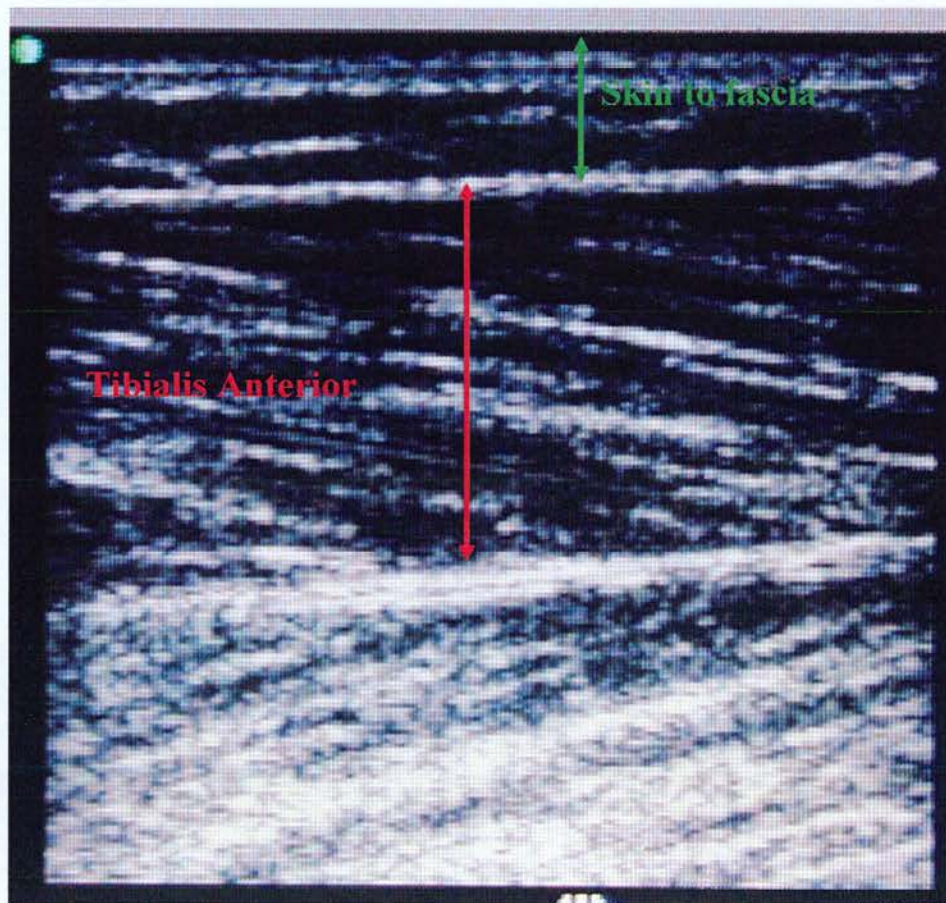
Ultrasound scan of superficial anterior leg compartment. Red arrow = distance from skin surface to deep fascia. Green arrow = deep fascia to posterior border of tibialis anterior
